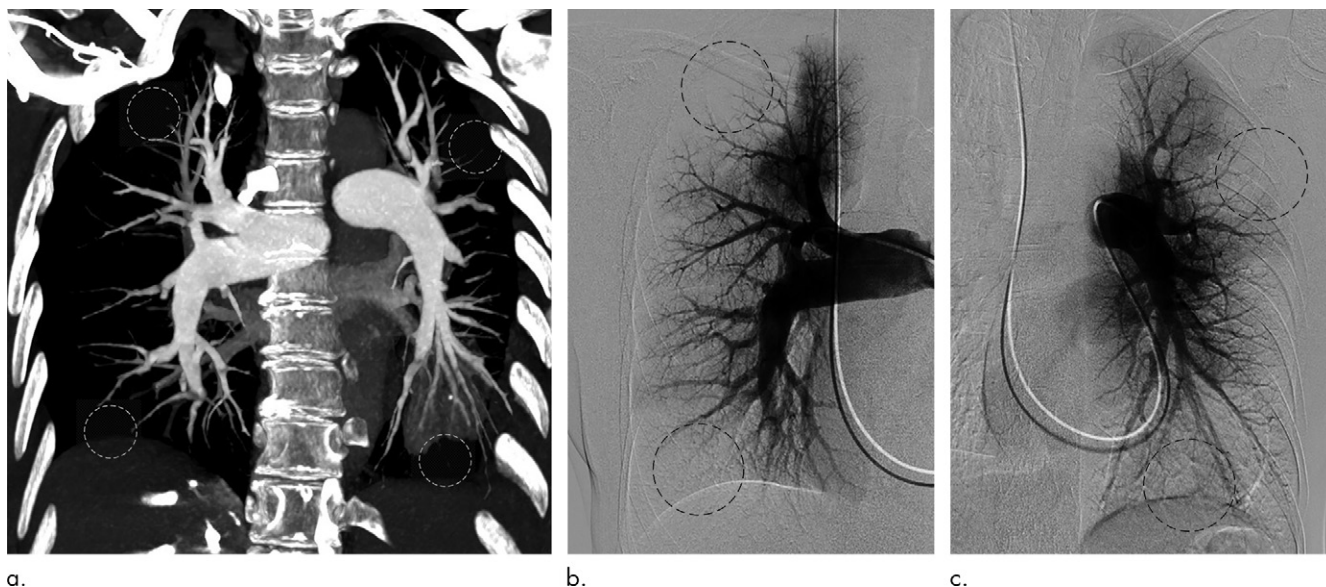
(a–c) Images show CT angiography and pulmonary angiographic evaluation in a 28-year-old patient with peripheral chronic thromboembolic pulmonary hypertension. Maximum intensity projection (coronal plane) (a) and corresponding right (b) and left (c) anteroposterior views of digital pulmonary angiographic study. Presence of vessel pruning and poor distal perfusion (dotted circles) on peripheral pulmonary arteries on CT angiographic reformat and corresponding perfusion defects (dotted circles) on angiographic views.
